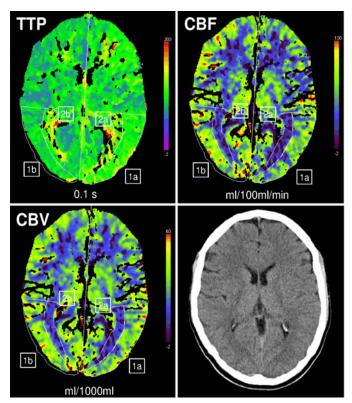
Perfusion computed tomography shows hypoperfusion of the entire left hemisphere, predominantly in the left Broca's and occipitotemporal region (time to peak + cerebral blood flow), while cerebral blood volume is above ischemic thresholds (over 60% of average cerebral blood volume in corresponding contralateral unaffected area). Left regions of interest are used for quantification, mirrored regions of interest on the right side. Abbreviations: TTP: time to peak; CBF: cerebral blood flow; CBV: cerebral blood volume; 1: cortical Region of Interest; 2: subcortical Region of Interest, a: hypoperfused tissue; b: normal tissue. Right bottom: non-contrast computed tomography at the level of perfusion CT
